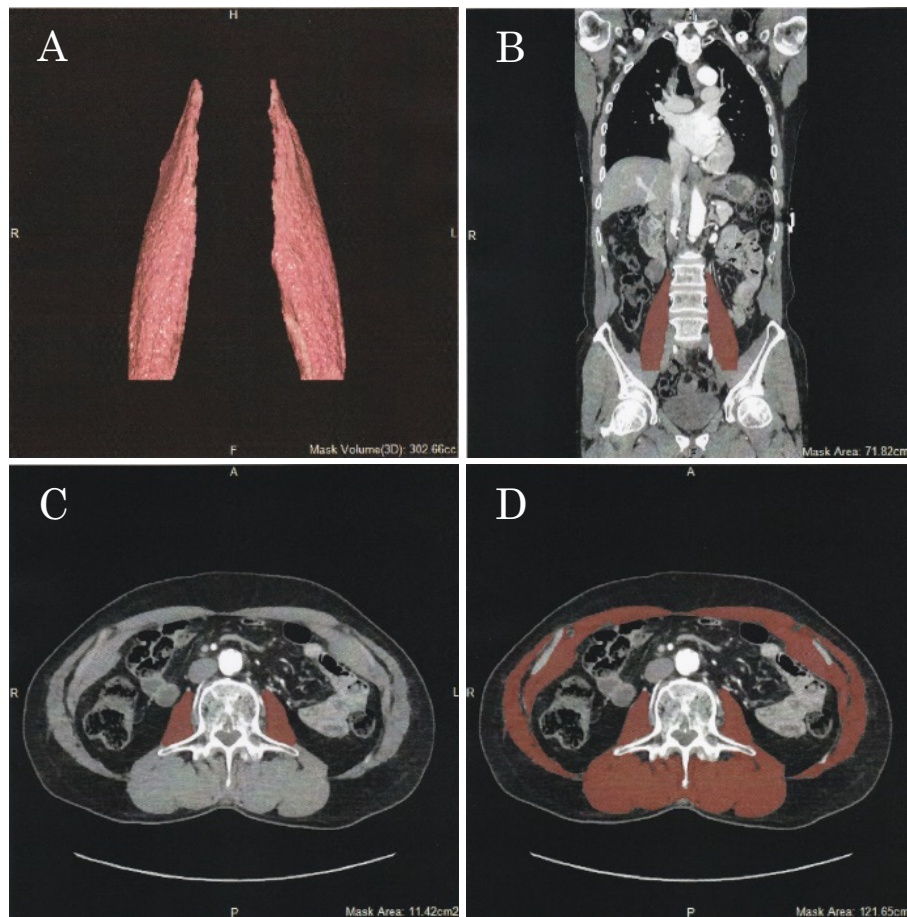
Assessment of skeletal muscle in CT images.
